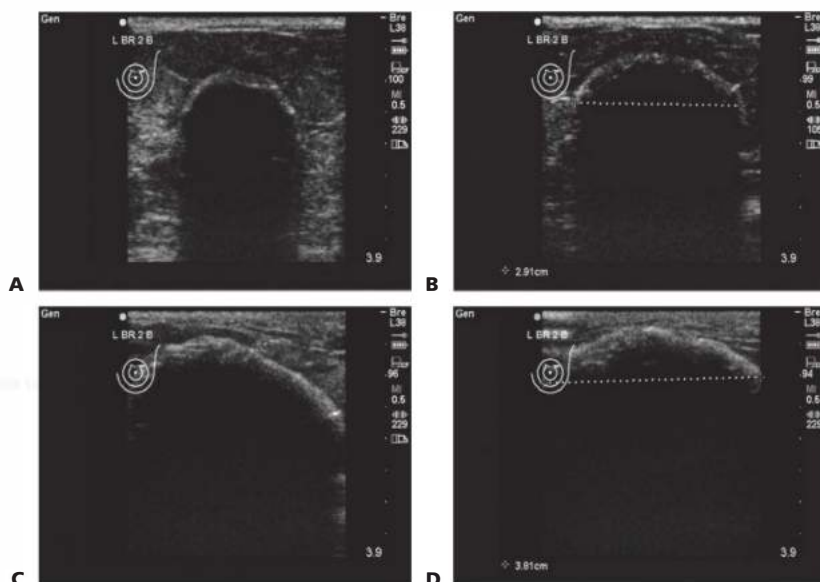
• Serial Ultrasound Images of Cryoablation A. During initial iceball development. B. Transverse view of iceball at the end of first freeze cycle. C. Longitudinal view of iceball at end of second freeze cycle. D. Transverse view of iceball after cryoprobe removal.
